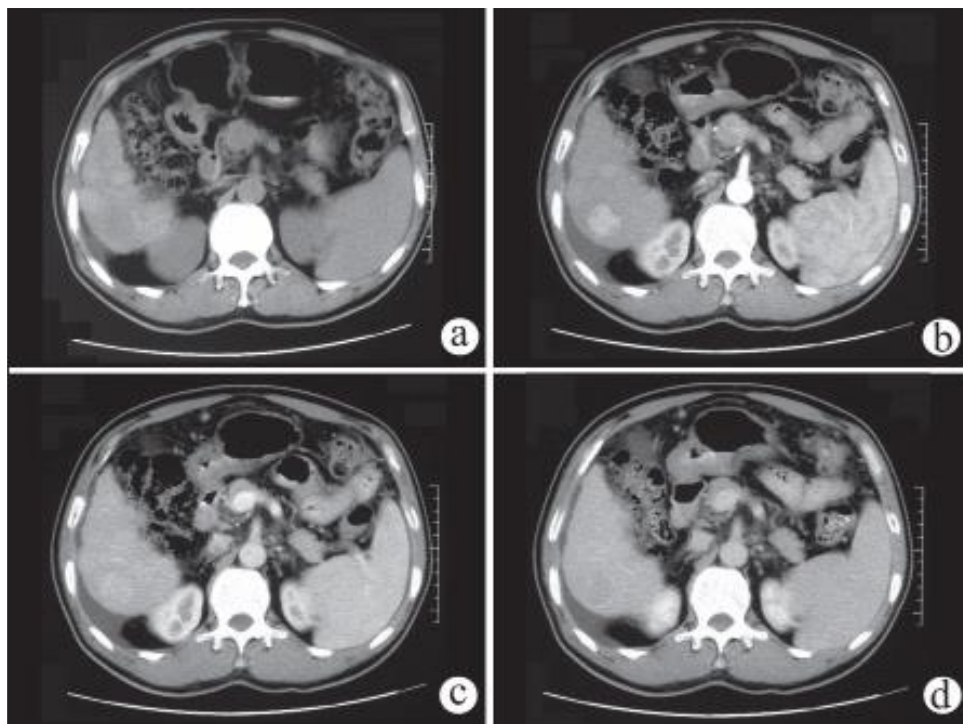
Multiphase enhanced CT of a HCC associated
